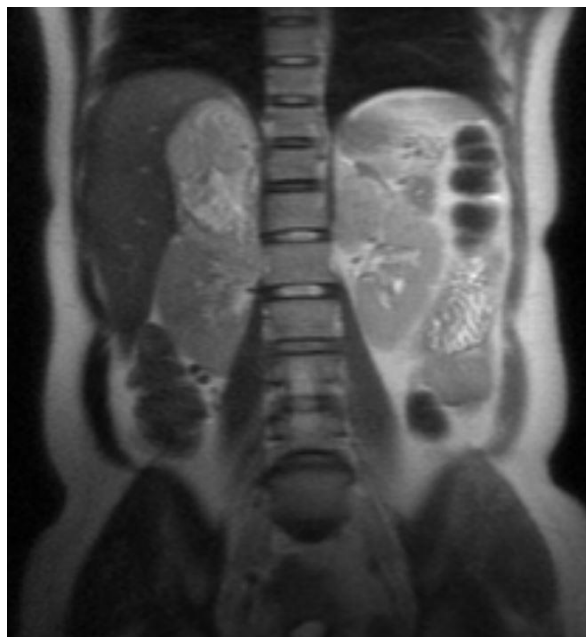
Magnetic Resonance Imaging showing heterogeneous expansile formation in the right adrenal gland (Axial Section)).
